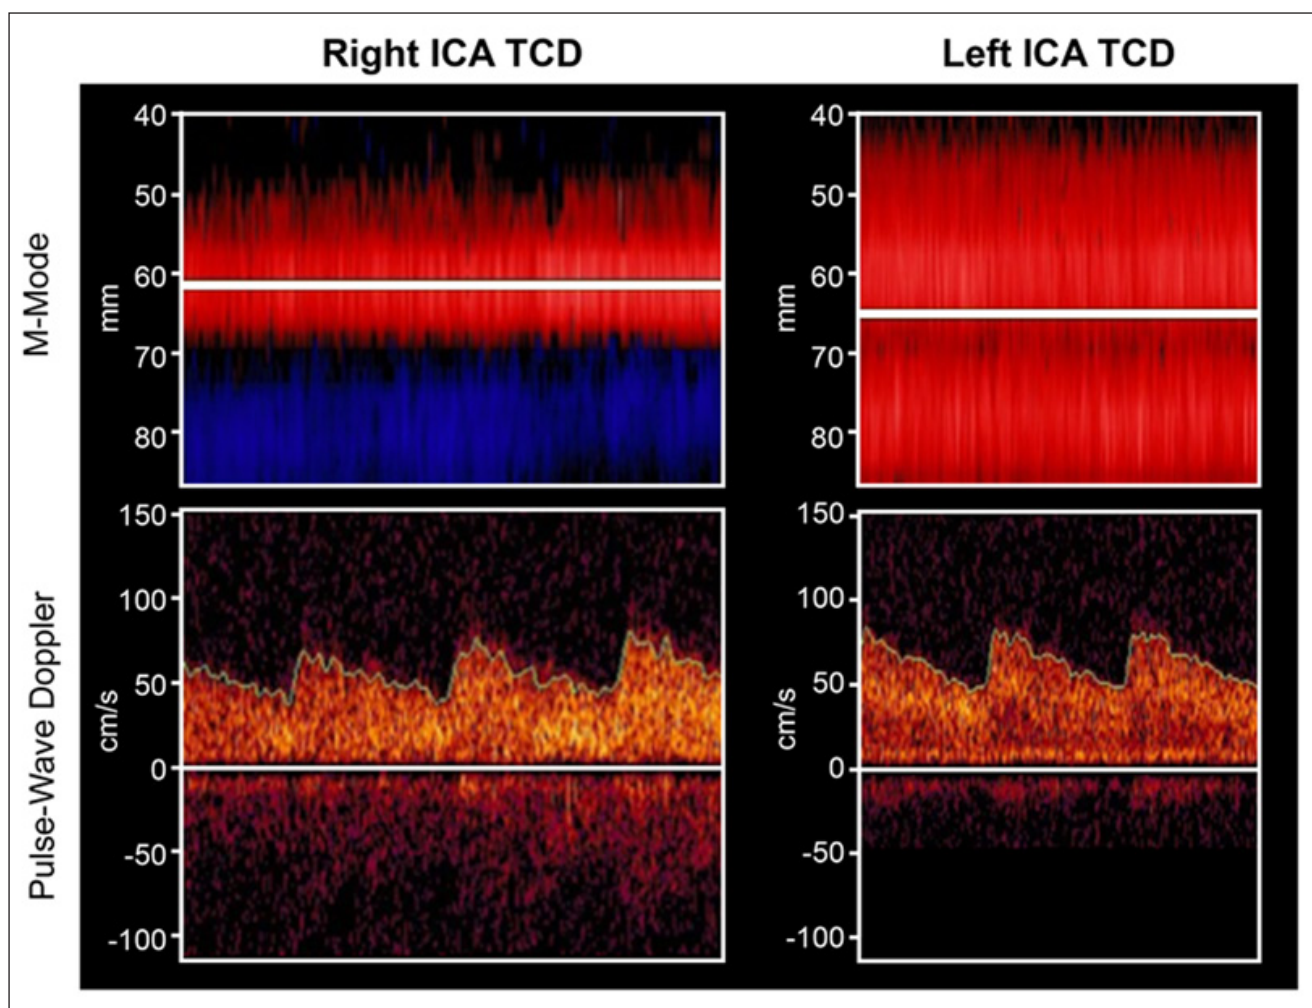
Transcranial Doppler image of the left and right middle cerebral arteries (MCA). Unexpectedly normal left MCA waveform. ICA: internal carotid artery; TCD: transcranial Doppler
